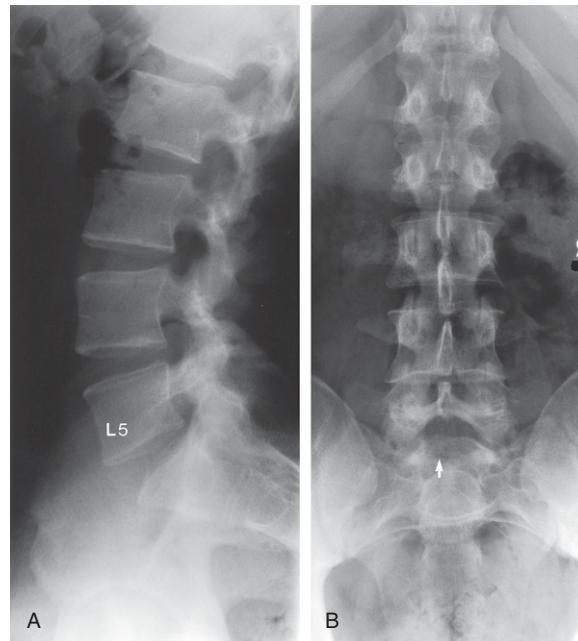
(A) A normal lumbosacral spine lateral plain X-ray image. L5 = fifth lumbar vertebra. (B) A normal lumbosacral spine anteroposterior plain X-ray image apart from a very minor spina bifida occulta at the S1 level (arrow).
